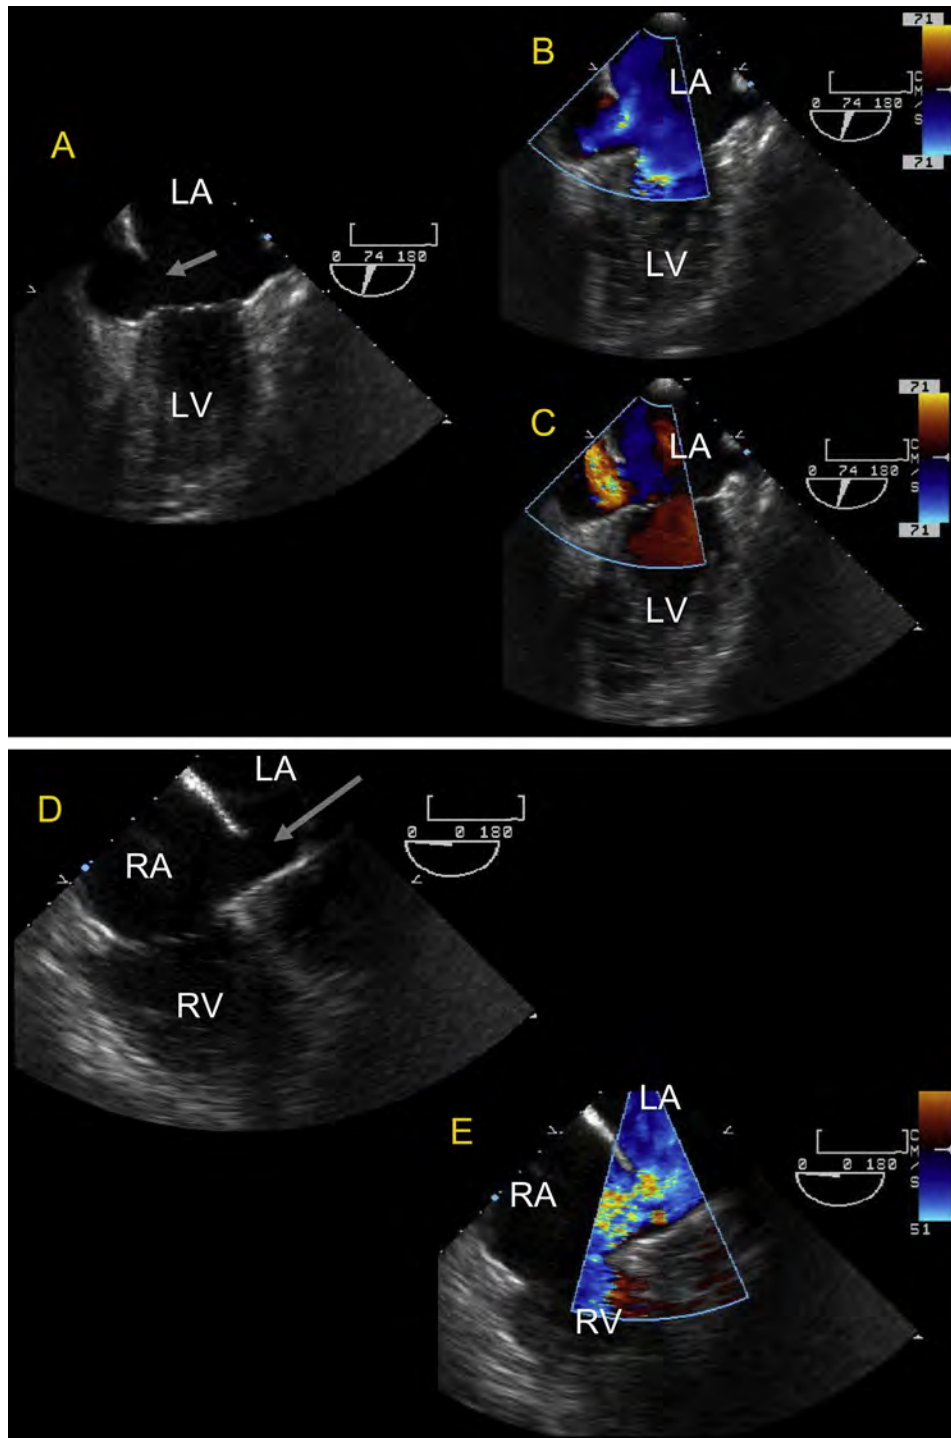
Two-dimensional TEE of unroofed coronary sinus. (A) Two-dimensional image demonstrating enlarged coronary sinus with unroofing communicating with LA (*arrow*). (B and C) Color Doppler flow into the coronary sinus from the LA and into the RA, creating an interatrial communication through the unroofed coronary sinus. (D) Two-dimensional image demonstrating enlarged coronary sinus with unroofing communicating with LA (*arrow*). (B and E) Color Doppler flow into the coronary sinus from the LA and into the RA, creating an interatrial communication through the unroofed coronary sinus. See also [Video 13](#).
